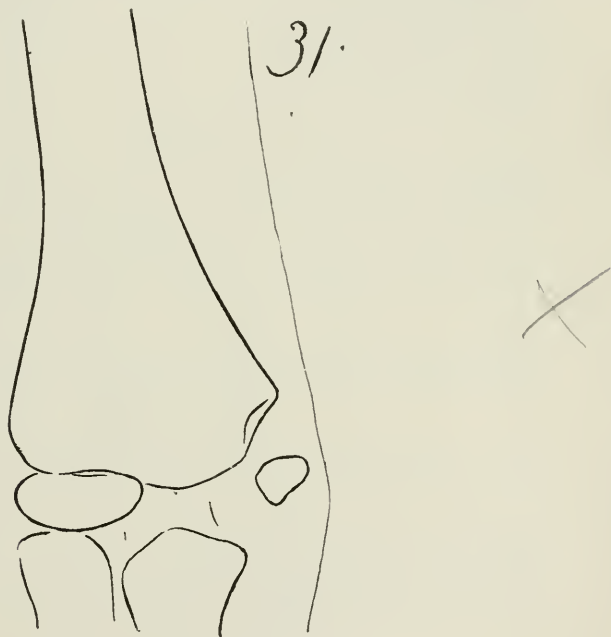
Case XXXI (X-ray tracing) (at three months).
